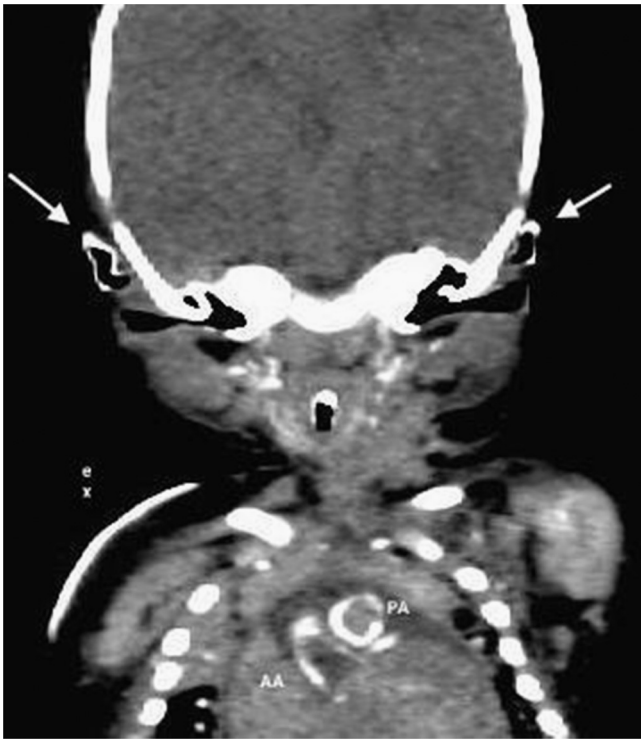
Coronal CT demonstrates bilateral ear cartilage calcification (white arrows). There is also calcification of the aortic arch (AA) and pulmonary artery (PA).
